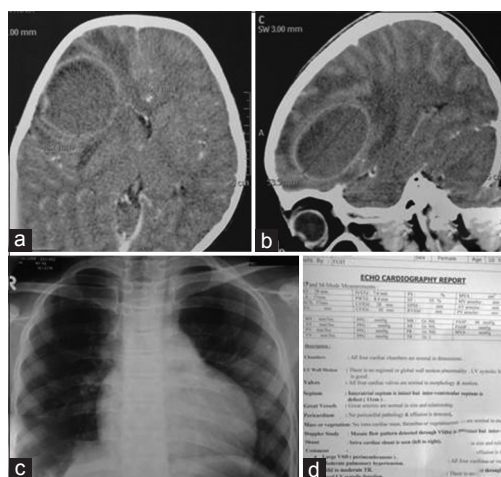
Preoperative contrast computed tomography scan of brain (a: axial section; b: sagittal section) showing right-sided posterior frontal brain abscess in child with tetralogy of Fallot; (c) X-ray chest P/A view showing "boot shaped" heart shadow; (d) echocardiogram report
